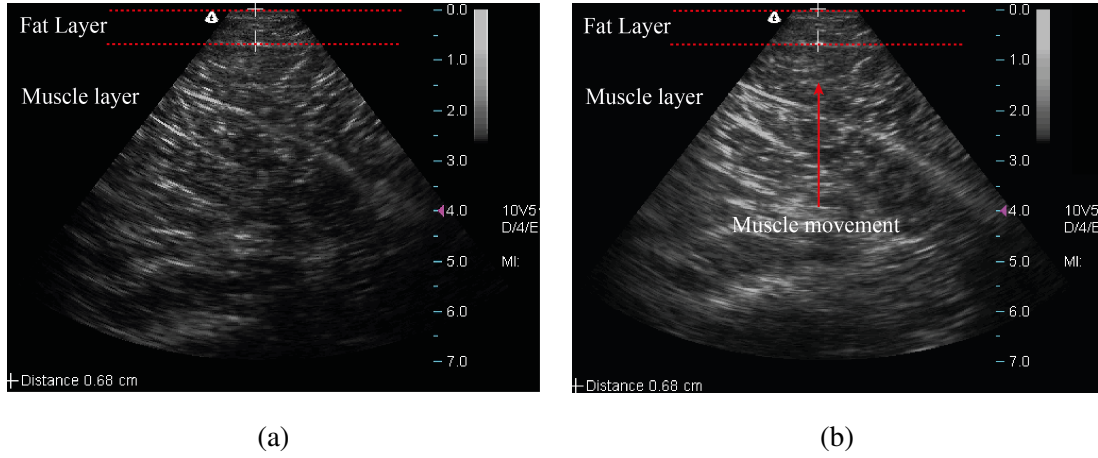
Measured fat thickness on subject calf using ultrasound imaging at different states.
